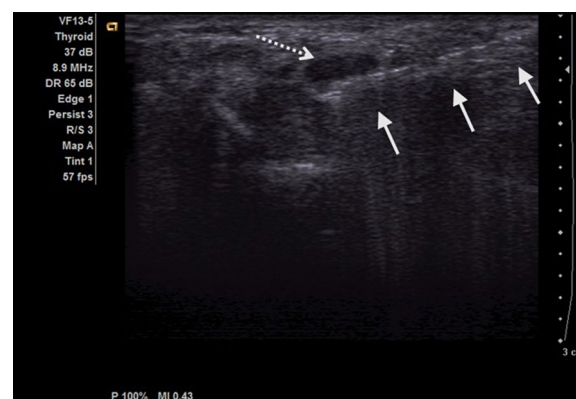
Ultrasound image at the level of proximal carpal tunnel, shows a needle (white arrow), targeting the posterior aspect to the median nerve (dashed arrow) to deliver steroids
